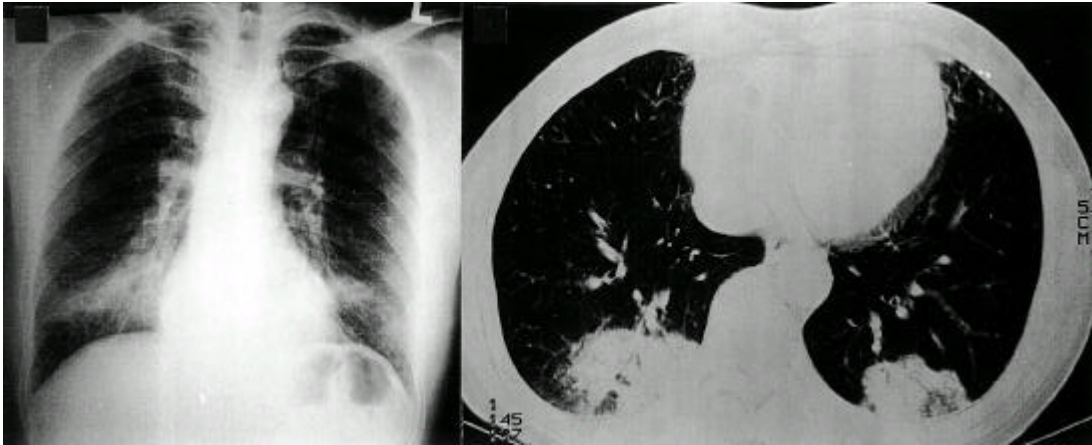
Chest radiograph and HRCT on admission showing focal patchy airspace consolidations in the subpleural space of both basal lungs.
